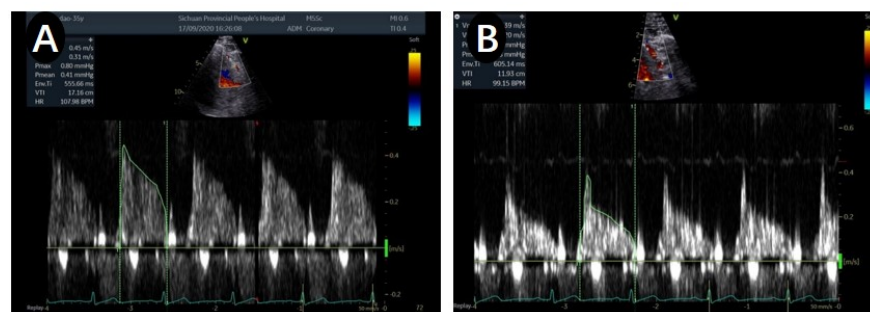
Changes of blood flow spectrum in the distal segment of left anterior descending coronary artery by transthoracic ultrasound. In the recovery period(B), the coronary flow spectrum resistance increased significantly and the blood flow velocity integral decreased compared with that before ATP stress(A).
